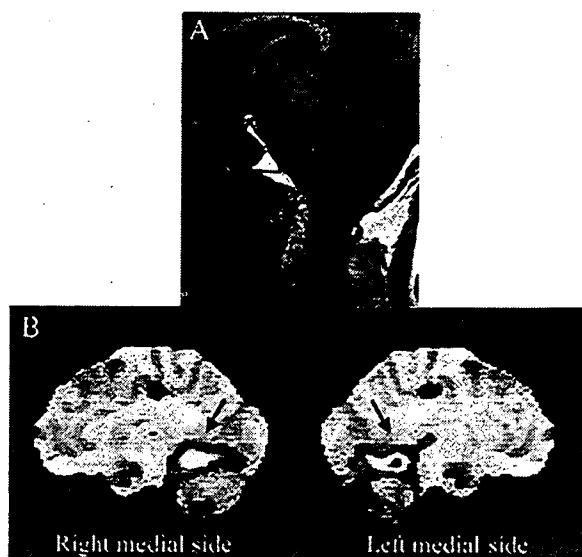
(A) Brain MRI of the patient. Brain MRI revealed cerebellar superior vermis atrophy without brainstem atrophy. (B) ^{123}I -IMP SPECT with 3D-SSP analysis. The results showed decreased blood flow in the superior cerebellar vermis (arrow) and cerebellar hemisphere.
